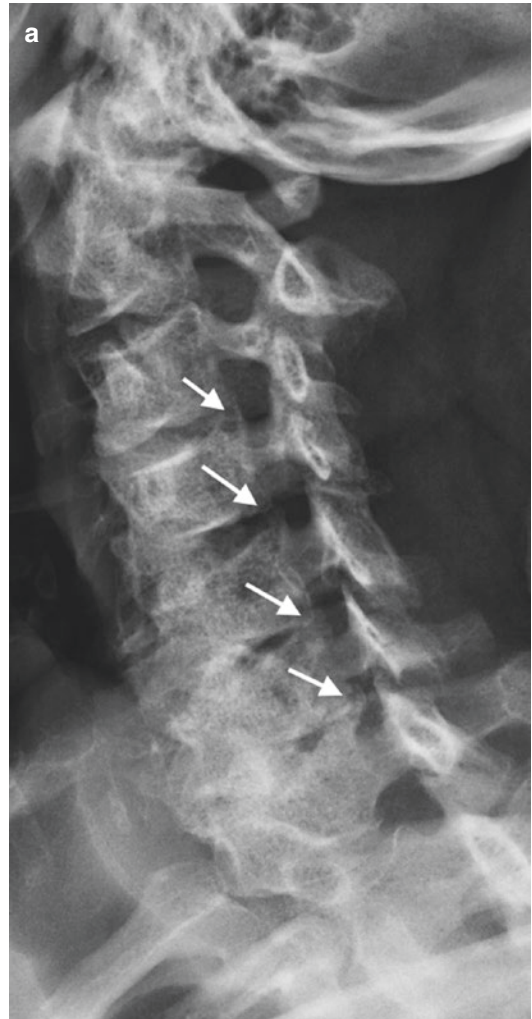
Oblique radiographs cervical spine demonstrating (a) left neural foramina with mild to moderate stenosis, gradual worsening as one extending inferiorly, secondary to uncovertebral and degenerative disc disease with loss of height and endplate osteophytes (arrows) and (b) normal left oblique for comparison
